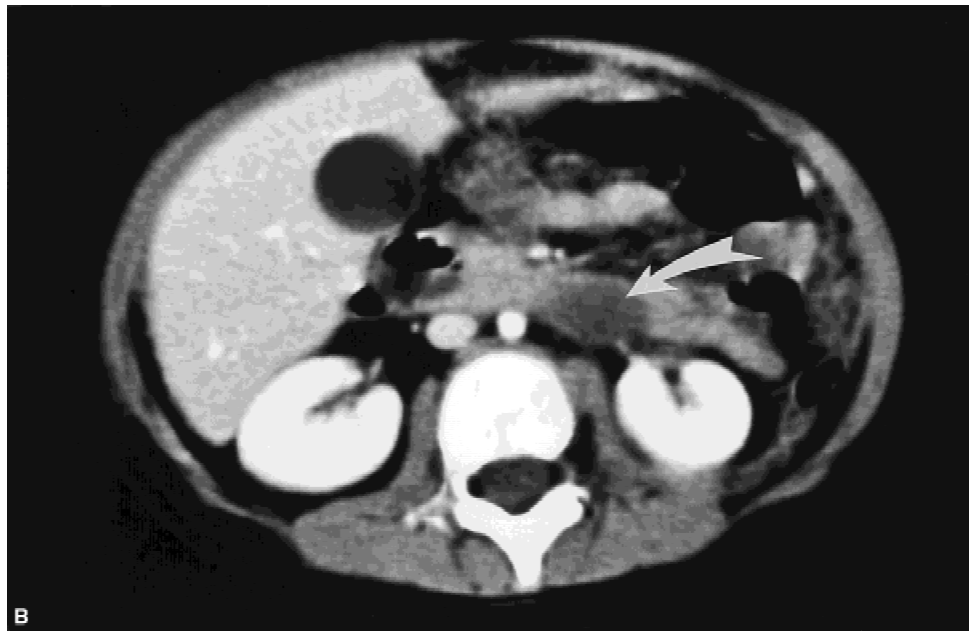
A small pseudocyst (arrow) remains in the body of the pancreas. Note that the level of the CT scan in 1B is different than in 1A to show the widest diameter of the pseudocyst in each case.
